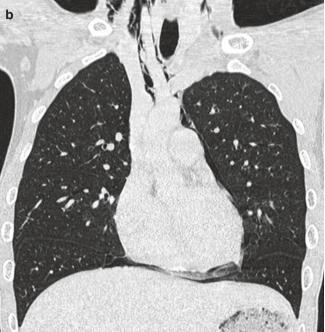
Spontaneous pneumomediastinum in an 18-year-old man. (a) "Continuous diaphragm" sign (black arrow) with left paracardiac lucency (arrowheads), paratracheal streaky lucencies, and right supraclavicular emphysema (white arrow). (b) CT
